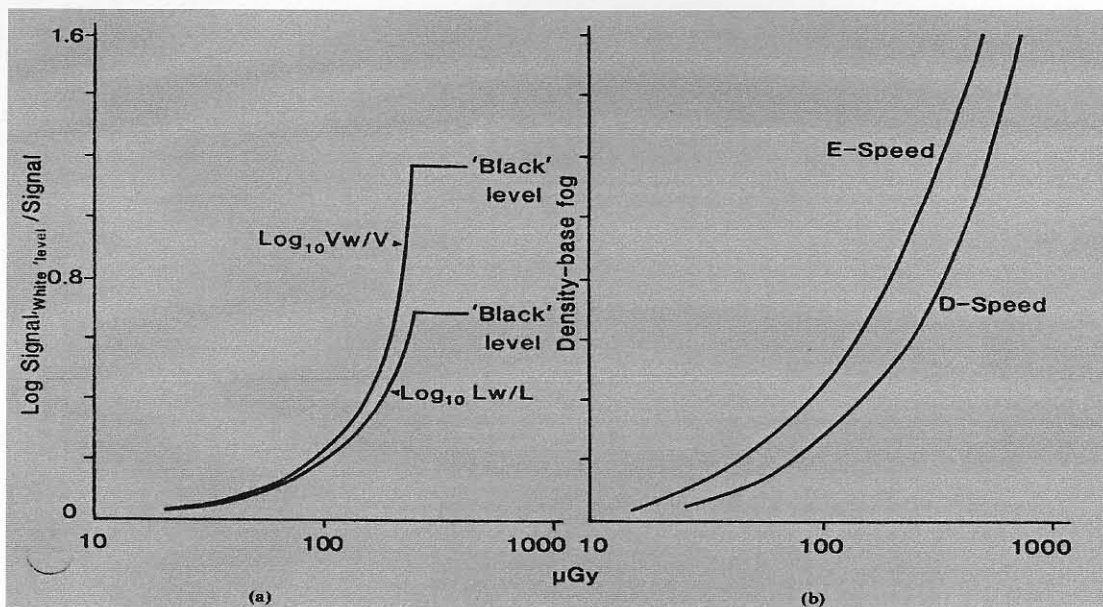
Characteristic Curve for Conventional X-ray Images and an Analog For Digital Images
